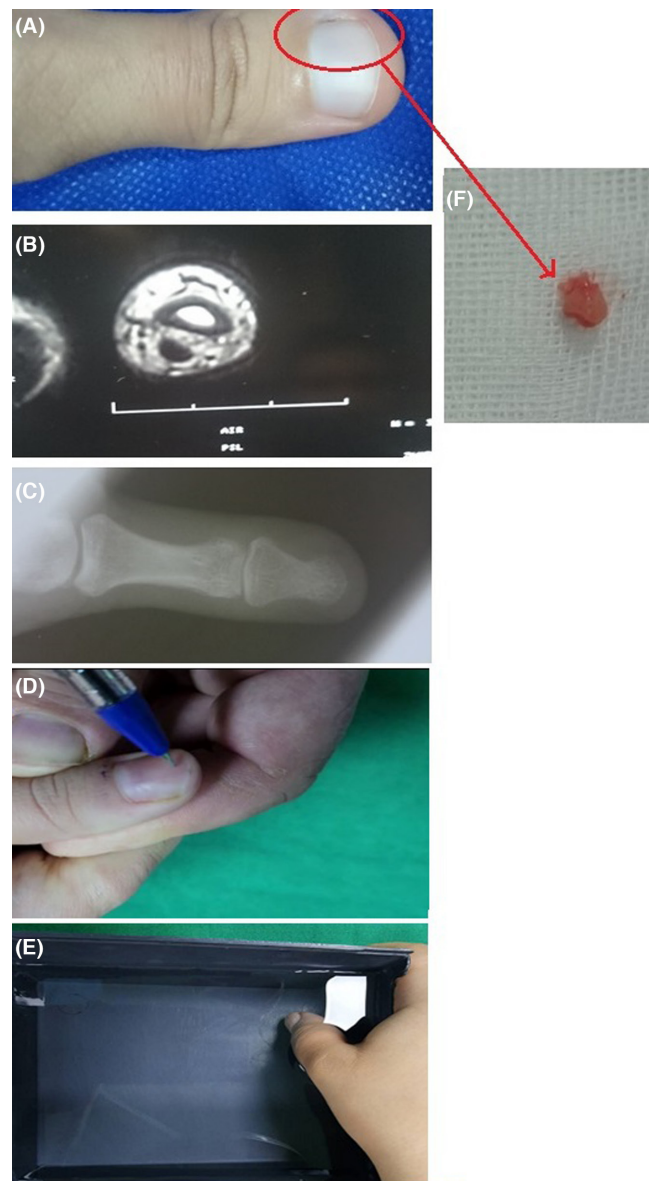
The subungual glomus tumor (GT) area was examined physically (A), followed by a T-1-weighted CT scan (B) and plain radiography (anterior–posterior [A-P] view; (C) of the thumb to determine the area for nail removal (D). The distal phalange of the thumb was then placed in warm water (at 55°C) (E), and the GT was successfully removed, measuring 0.4 × 0.4 cm (F).
